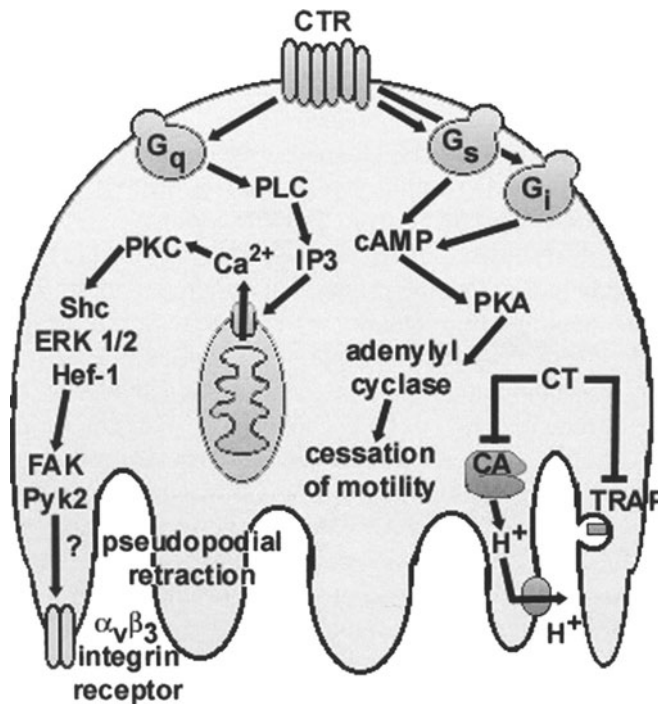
Effects of calcitonin on osteoclasts. Signaling from the calcitonin receptor (CTR) activates the G_s/G_i proteins leading to cessation of motility, and activates G_q proteins leading to pseudopodial retraction. Calcitonin (CT) alters the location of carbonic anhydrase (CA) thus inhibiting acidification, and also inhibits the release of tartrate-resistant acid phosphatase (TRAP) (lower right corner).
